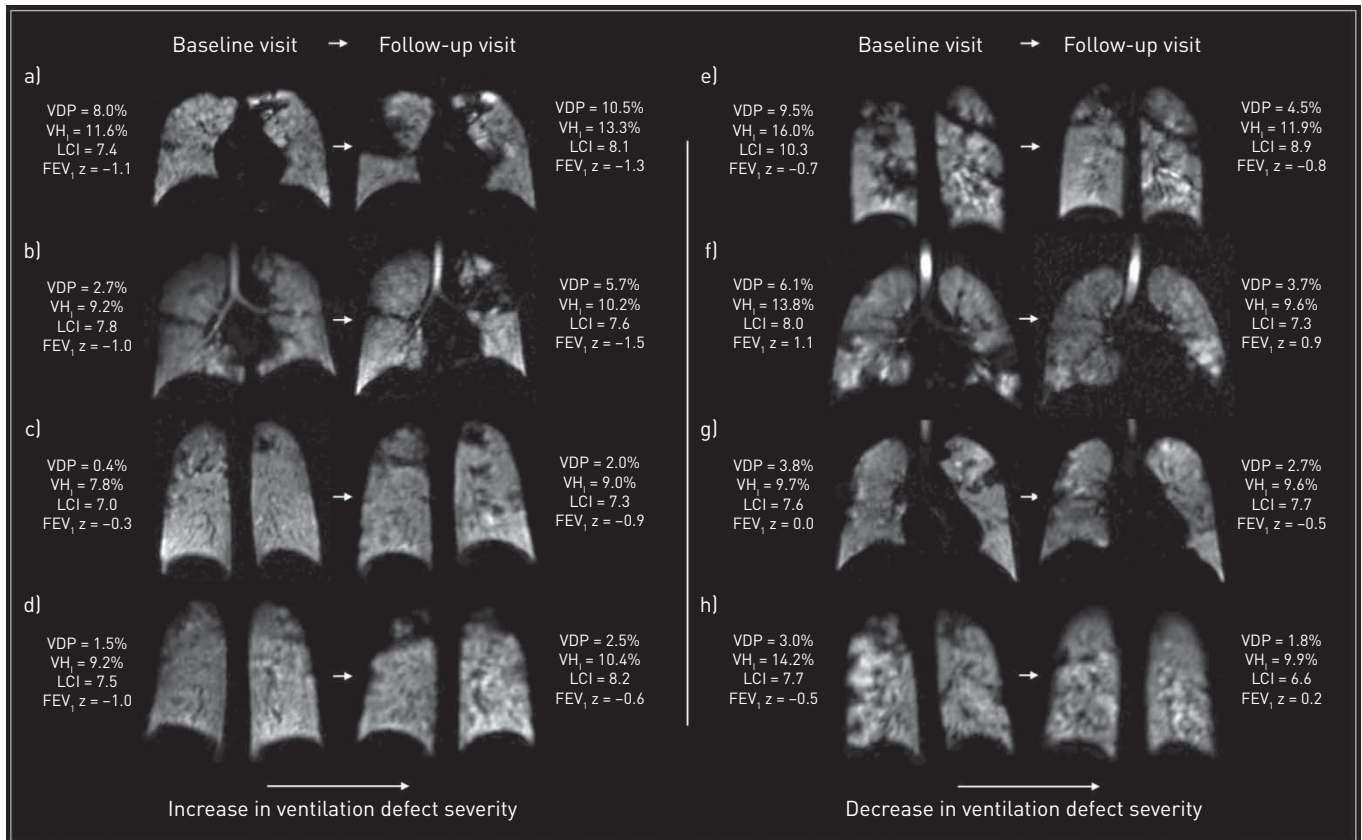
Eight longitudinal xenon-129 magnetic resonance imaging examples from patients with normal forced expiratory volume in 1 s (FEV₁) values. a–d) Patients with both a visible increase in ventilation defect severity and increase in ventilation defect percentage (VDP) over time; e–h) patients with both a visible decrease in ventilation defect severity and in VDP over time. VH₁: ventilation heterogeneity index; LCI: lung clearance index.
